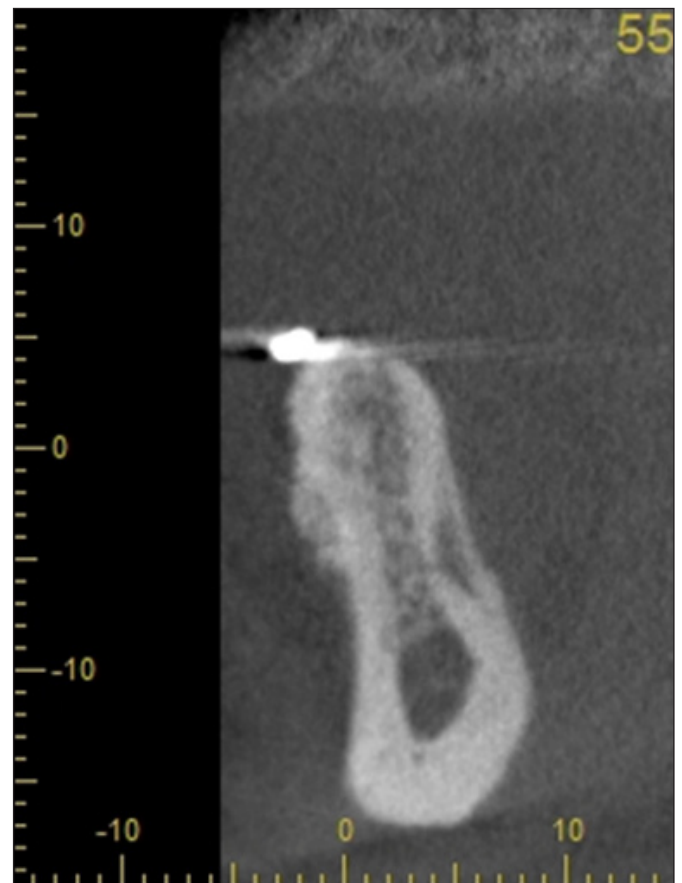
CBCT image of augmentation site nine months after augmentation.
